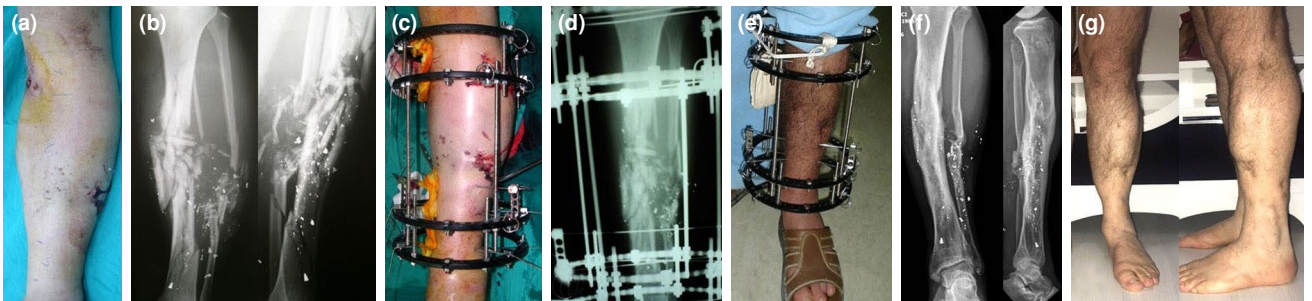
A-16-year follow-up of a 22-year-old troop injured by bomb explosion and shrapnel. (a) Clinical picture of wounded extremity. (b) An anteroposterior and lateral radiograph of comminuted tibia fracture due to high ballistic injury. (c) Intra-operative photograph of extremity with Ilizarov external fixator. (d) An anteroposterior radiograph of fractured tibia and fibula after surgery. (e) View of weight bearing extremity after Ilizarov surgery. (f) An anteroposterior and lateral radiograph of tibia at 16 years of follow-up. (g) Anteroposterior and lateral views of extremity at 16 years of follow-up.
